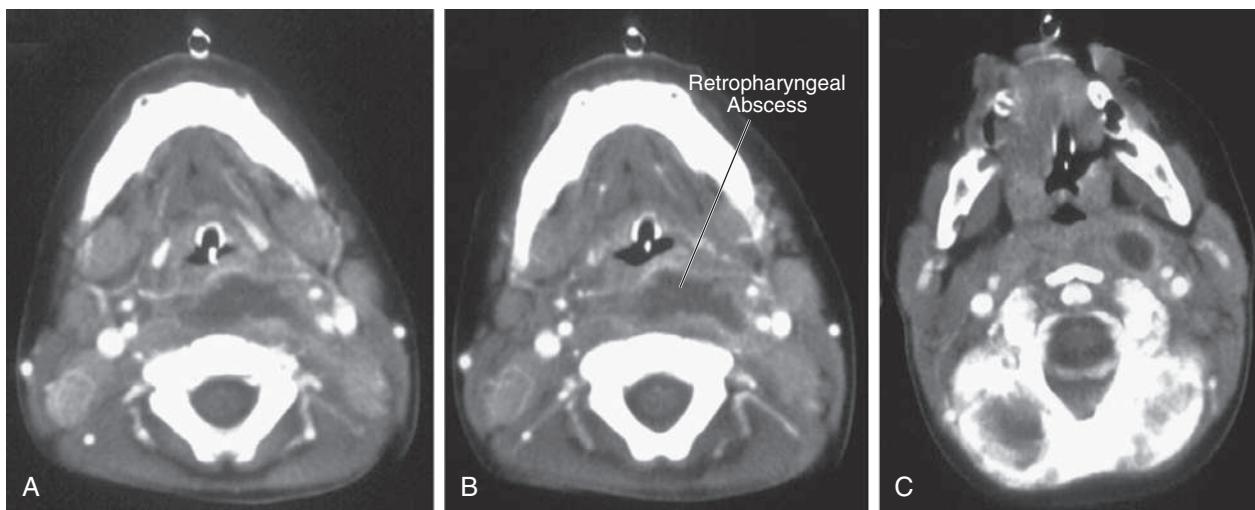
CT of retropharyngeal abscess. A, CT image at level of epiglottis. B, Sequential CT slice exhibiting ring-enhancing lesion. C, Further sequential CT slice demonstrating inferior extent of lesion. (From Philpott CM, Selvadurai D, Banerjee AR. Paediatric retropharyngeal abscess. *J Laryngol Otol.* 2004;118:925.)
